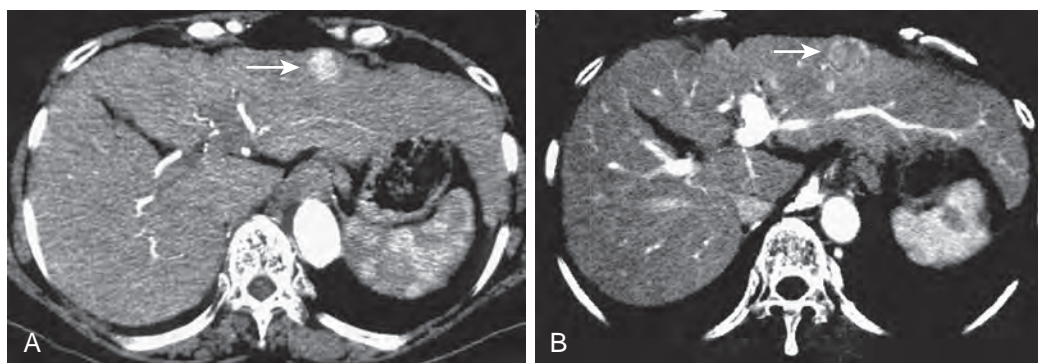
HCC: CT findings. A. Early arterial phase (25 seconds) contrast-enhanced CT scan shows a rapidly enhancing lesion in the left lobe of the liver (arrow). B. On late arterial phase image (40 seconds), HCC becomes less conspicuous because of early washout (arrow). (Courtesy Dr. Tomoaki Ichikawa, Yamanashi University, Yamanashi, Japan.)
